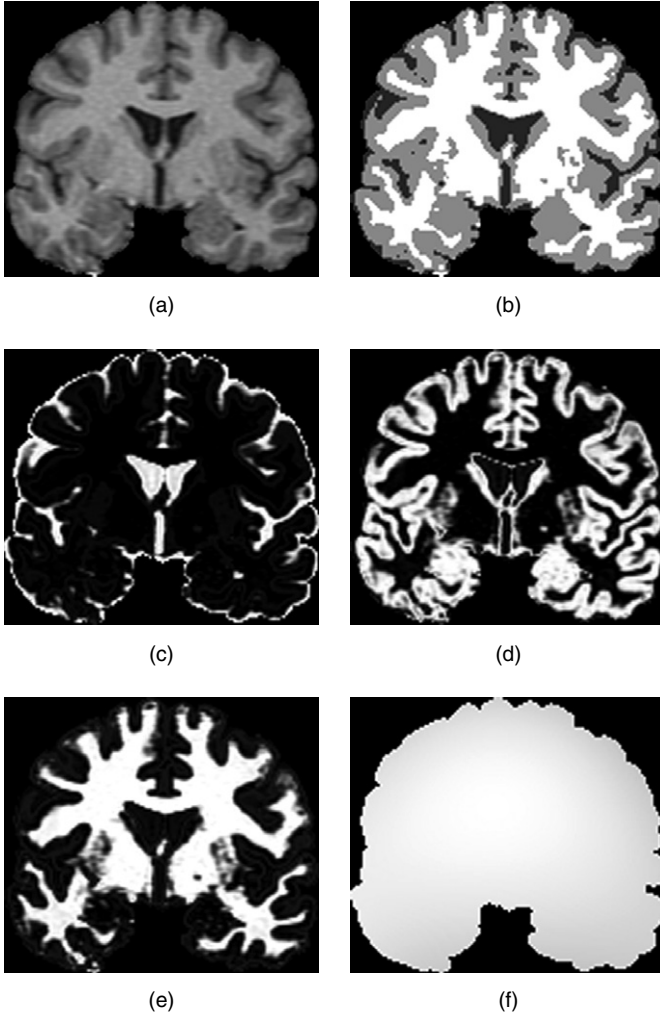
Robust fuzzy clustering example: (a) T1-weighted MR image, (b) final classification, (c) CSF membership function, (d) GM membership function, (e) WM membership function, (f) estimated inhomogeneity field.
